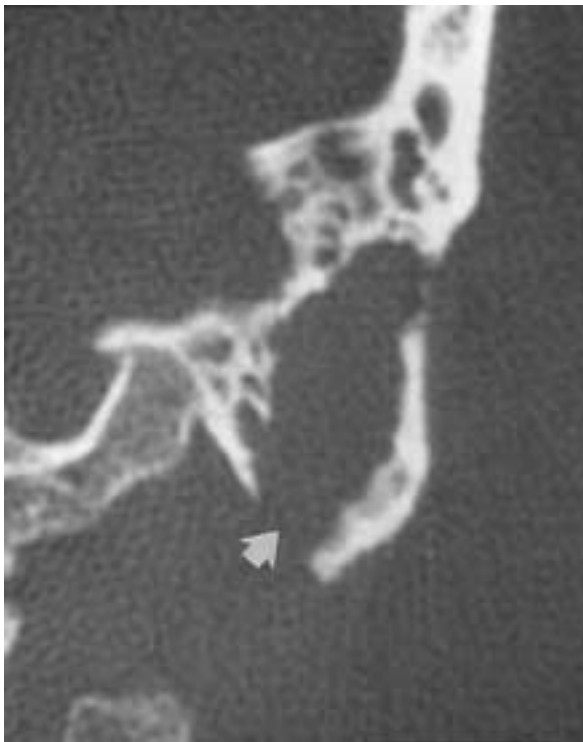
Mastoiditis (coronal CT) with erosion of the medial mastoid tip (arrow). This defect could allow infection to spread inferiorly into the neck, causing a Bezold abscess.
